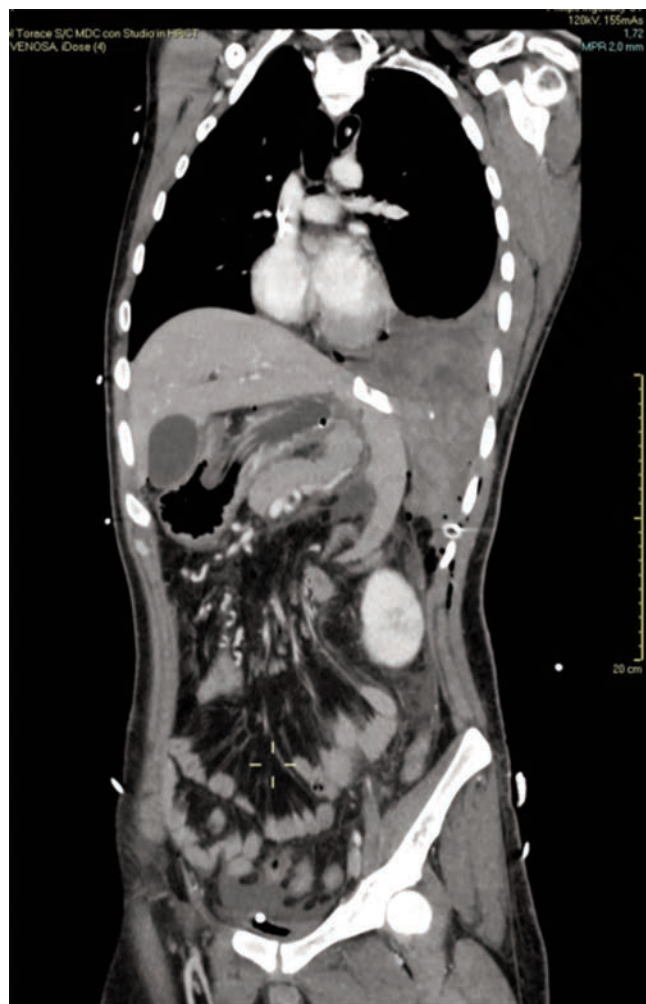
Contrast-enhanced computed tomography, coronal plane: imaging after surgical repair of the hernia.
